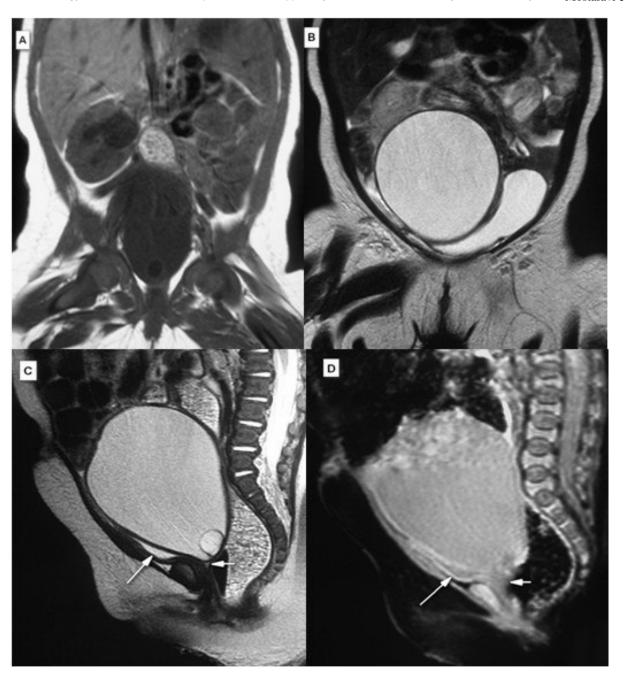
A 3-month-old girl with McKusick-Kaufman syndrome. MRI of abdominopelvic cavity: Coronal T1W (A), Coronal T2W (B), sagittal T2W (C), and sagittal GRE (D) reveal hydrometra, atretic cervix, compressed bladder (long arrow), and atretic proximal vaginal pouch (short arrow).
